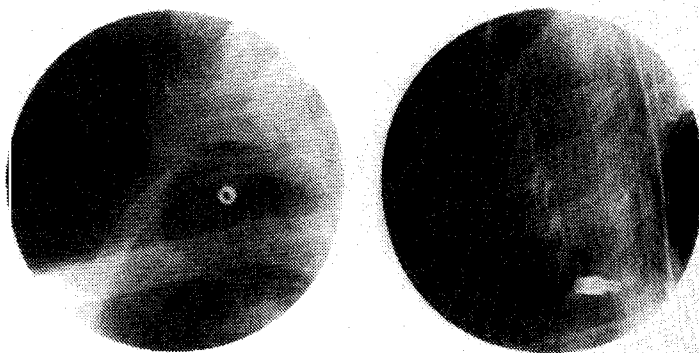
X-ray views of detached tip.
